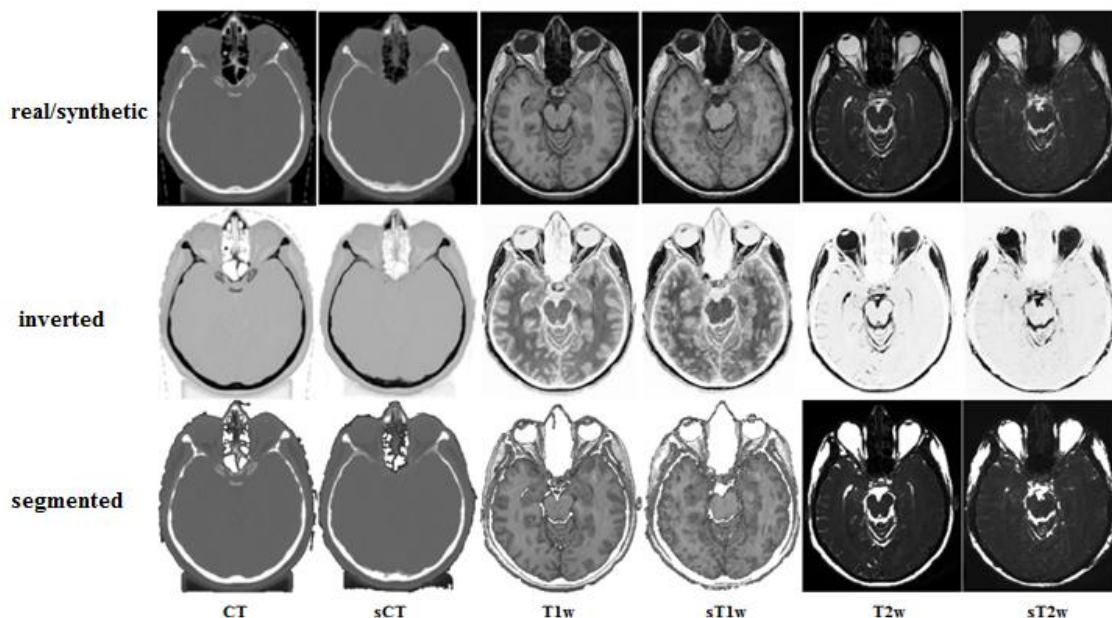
Inverted and segmented images of real and synthetic computed tomography and magnetic resonance imaging
